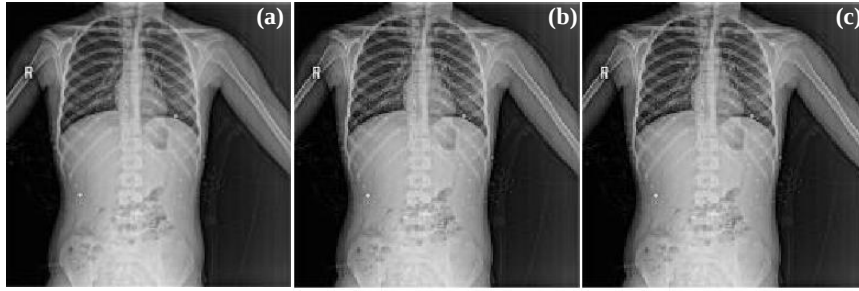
Gray Medical X-Ray Image with $X=1$; $U=1$: (a) Original X-Ray image, (b) Encrypted X-Ray image, and (c) Decrypted X-Ray image
